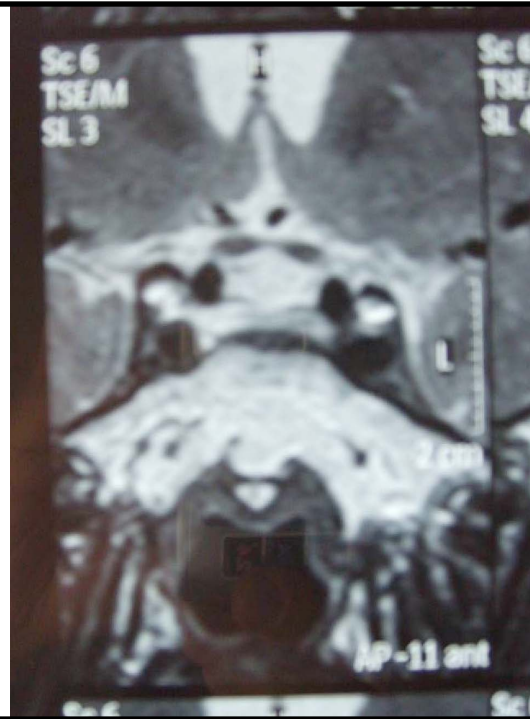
MRI scan of hypophysis showing a 4mm microadenoma on the right side of the adenohypophysis.
